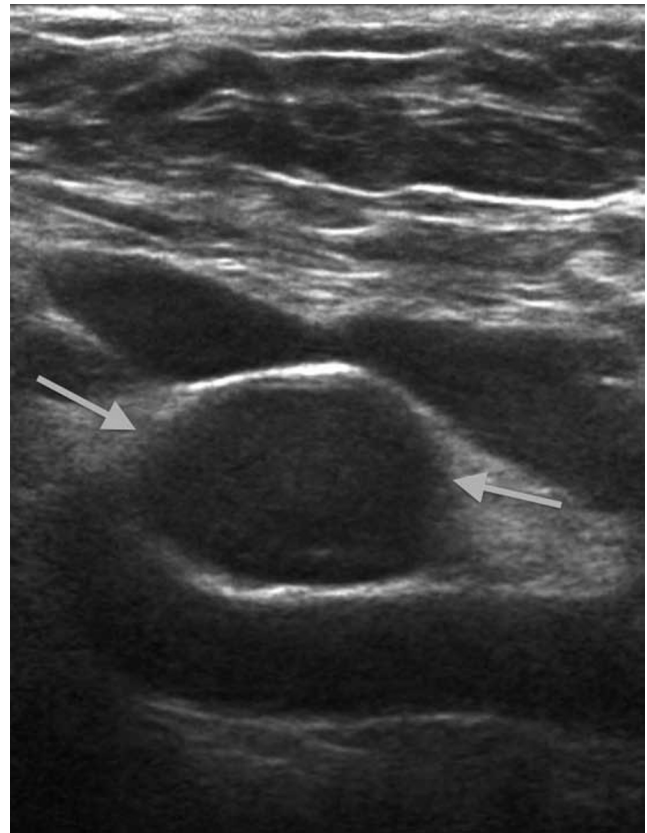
79-year-old woman with brachial plexus tumor. Right axillary nerve-sheath tumor. Longitudinal ultrasound image shows an oval circumscribed mass (arrows) with thin hyperechoic capsule between the axillary vein and artery.
